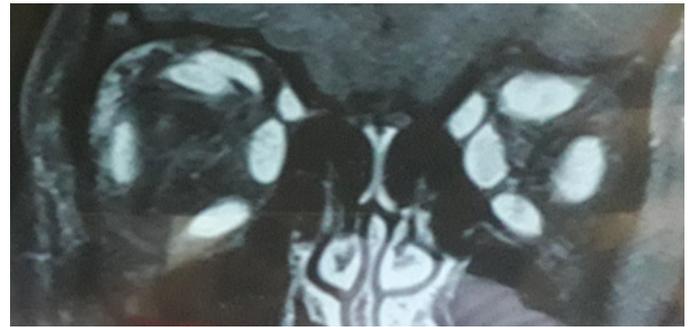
MRI without contrast: Diffuse thickening of the muscular bodies of the recti of both eyes is observed, including the levator palpebrae superioris muscle of the RE, causing the clinically evidenced ptosis.
